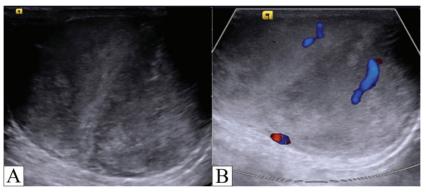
(A) shows large, mildly heterogeneous, well defined, solid lesion noted in the left hemiscrotum just abutting the left testis. (B) Doppler shows moderate internal vascularity within solid lesion in the left hemiscrotum.
